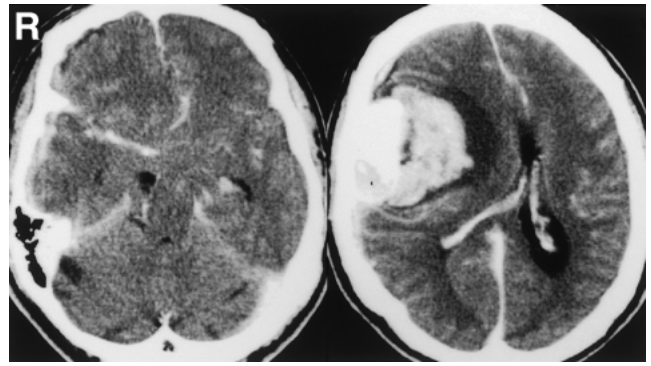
Case 2. Computed tomography scans showing a 4×2.4 cm well-enhanced mass lesion in the right frontotemporal convexity region, and massive hematoma in the brain tissue at the medial border of the lesion. Subarachnoid hemorrhage and acute subdural hematoma are also recognized. Marked midline shift is seen and the basal cistern is not visible.
